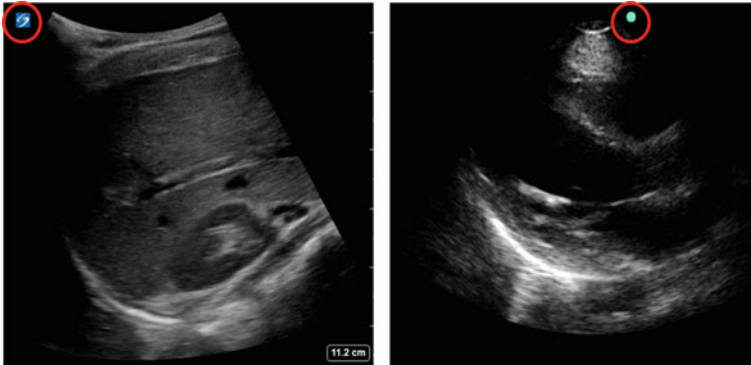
Orientation of marker dot in abdominal/chest ultrasound (left picture) and echocardiography (right picture)
